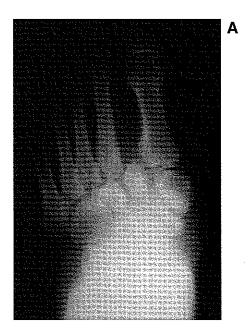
Anteroposterior (A) and lateral (B) radiographs obtained at initial diagnosis of Charcot's arthropathy of the left foot of Patient 1. Note the periosteal activity and lateral dislocation of the metatarsals on the anteroposterior view.
